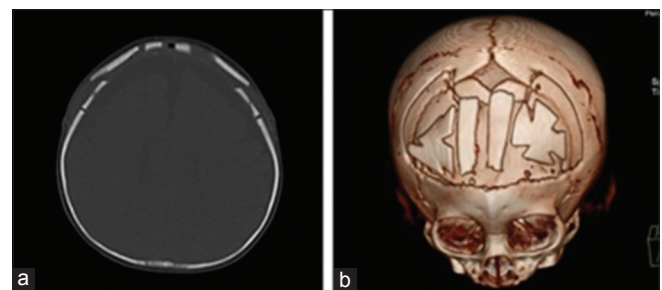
(a and b) Post-operative multidetector computed tomography volume rendering technique and bone window images showing multiple osteotomies appearing as “floating forehead”
